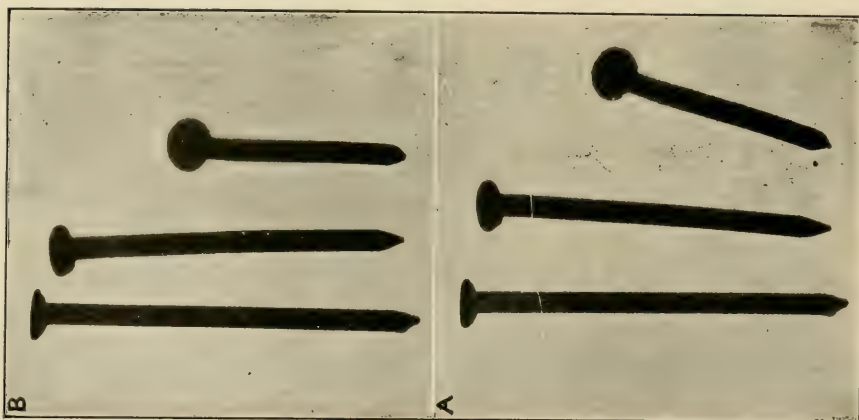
No stereoscopic effect at all is obtained with the radiographs mounted as in this figure.
